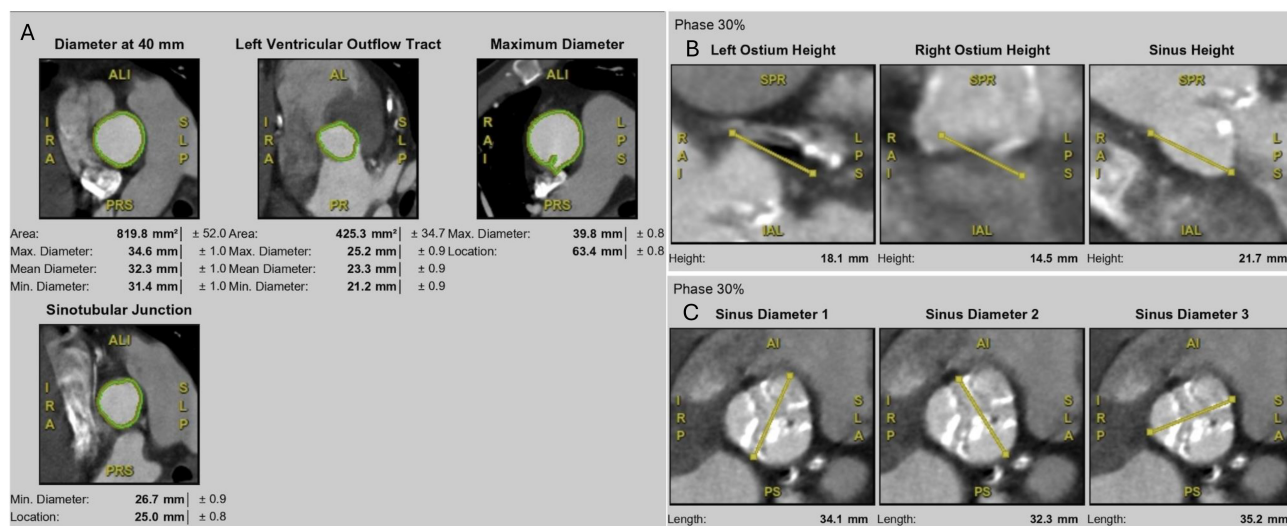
Multidetector CT measurements for TAVI planning. (A) Aortic root assessment at multiple levels, including annulus (diameter at 40 mm), LVOT, sinotubular junction (STJ), and maximum aortic root diameter. (B) Coronary ostium height measurements at 30% cardiac phase, including left and right coronary ostia and sinus height. (C) Sinus of Valsalva dimensions at 30% cardiac phase, showing three sinus diameters relative to the annular plane.
